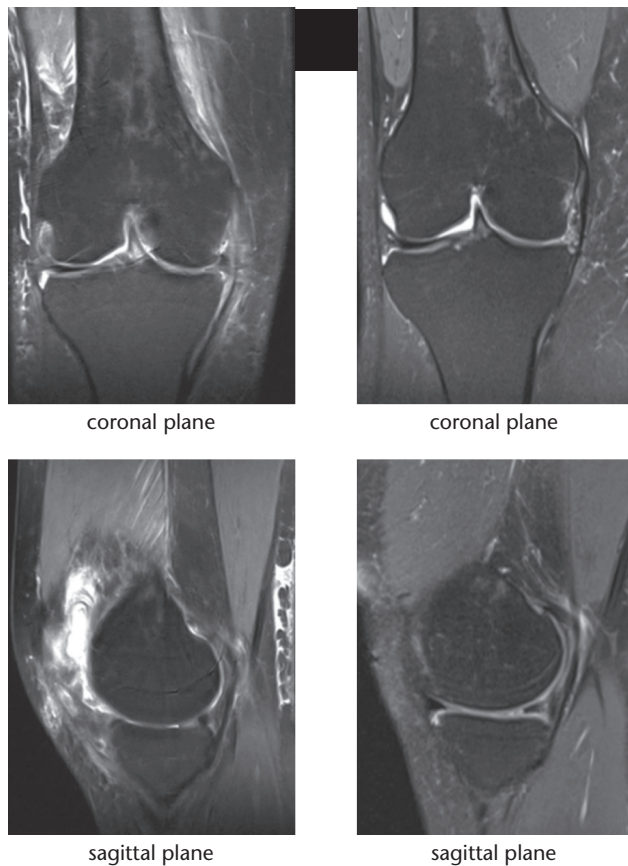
Partial meniscal replacement with collagen implant: magnetic resonance imaging (MRI) three months post-operatively (left) and 24 months post-operatively (right). Note that MRI signal indicates successful integration of the implant in the posterior horn three months post-operatively while the implant was obviously absorbed in the intermediate portion of the meniscus.
